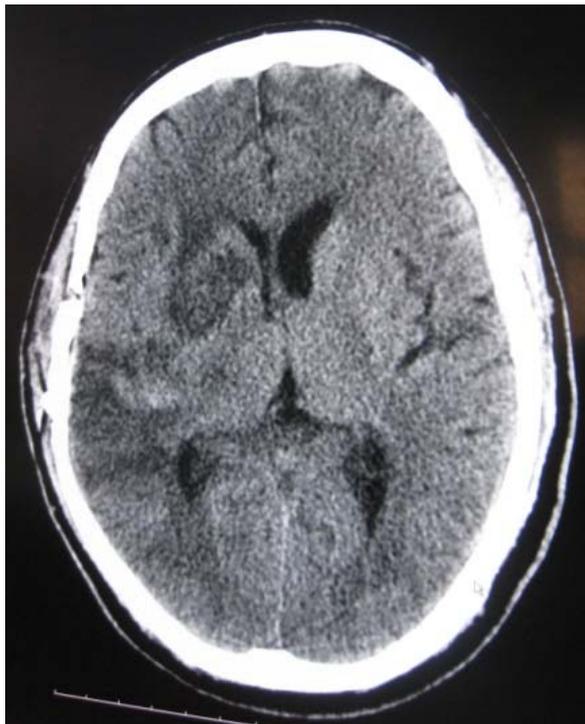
The CT findings after the right basal ganglia hematoma removal surgery.
